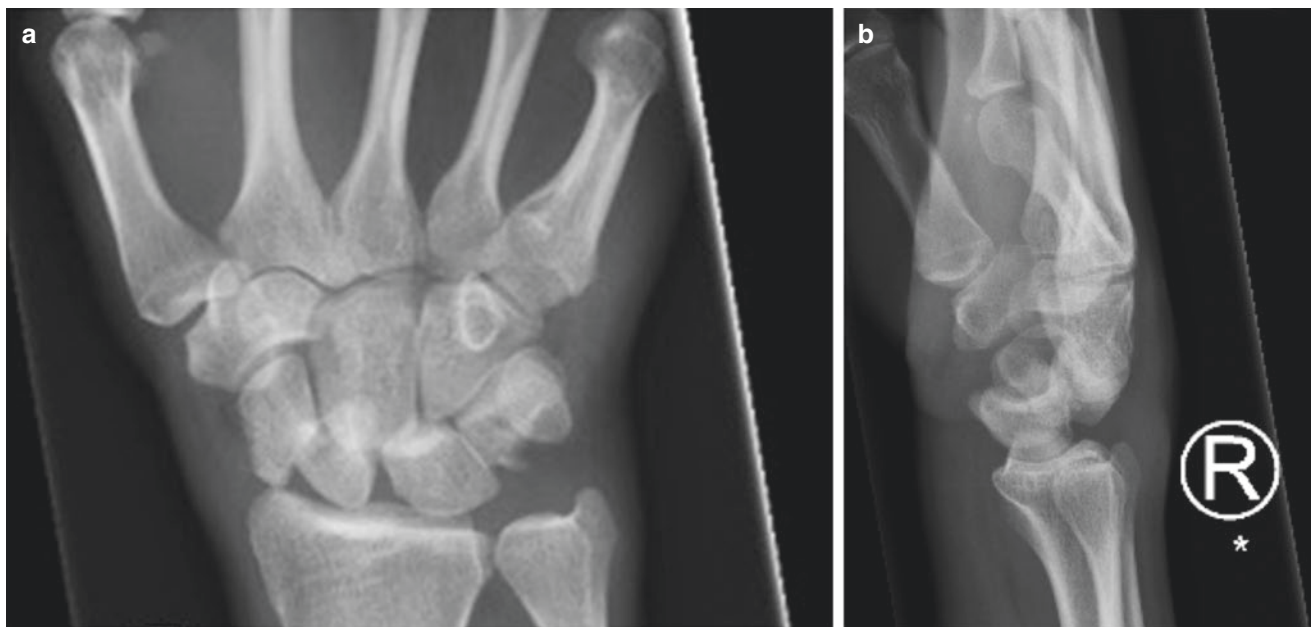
PA (a) and lateral (b) radiographs of a perilunate dislocation
